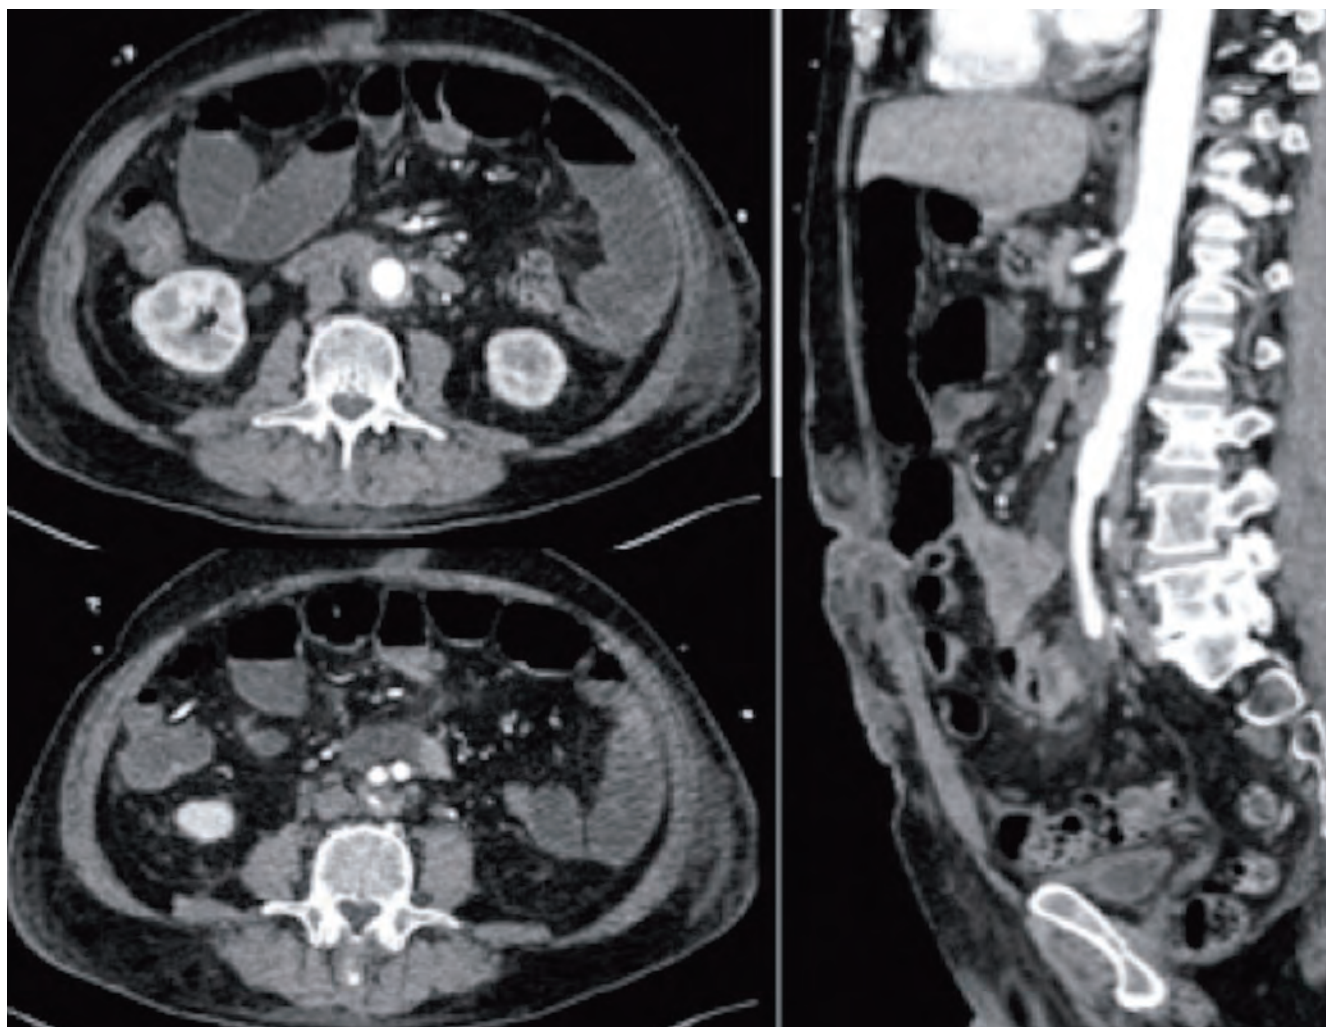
Control with contrasted abdominal CT where it is visualized in axial and sagittal sections.
